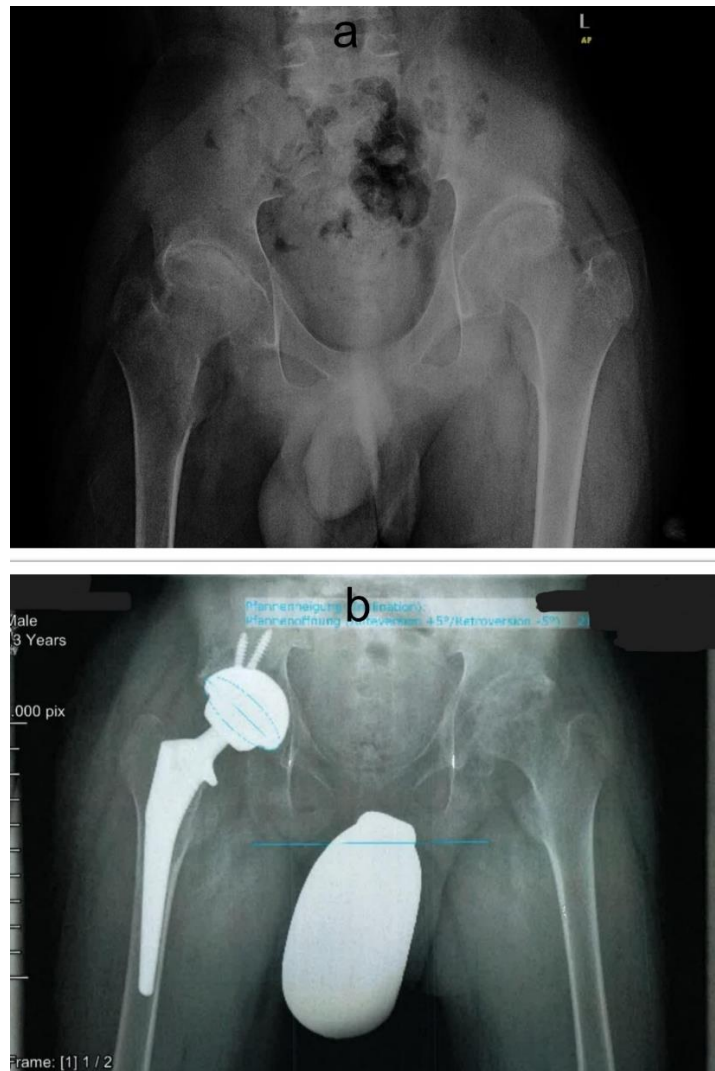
Plain x-ray of both hips AP, preoperative and postoperative at thirteen.
